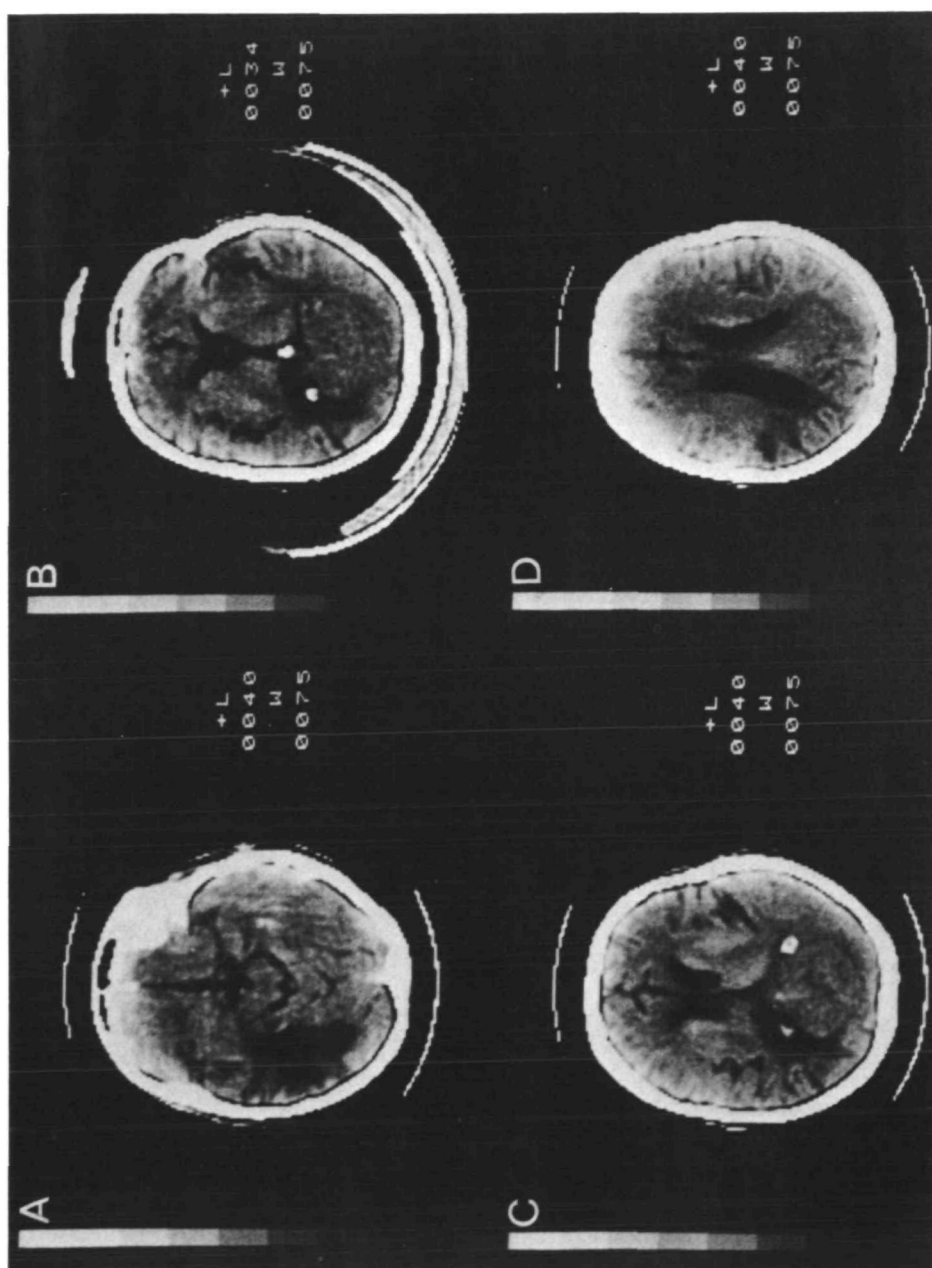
Results of CT scans obtained at four different levels. For details see text.
